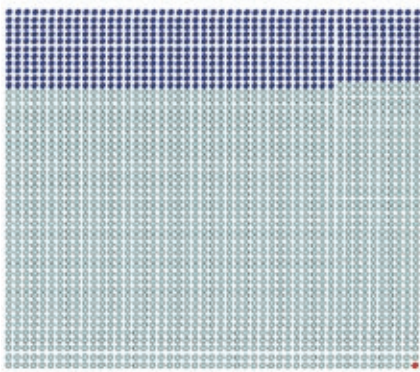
Communicating the risk of FDG PET scan. This pictorial approach may help patients understand the small risk of developing a fatal cancer as a result of this procedure. The red star indicates the risk of developing a fatal cancer (1/2500) [25]. (Used with permission of the Journal of Nuclear Medicine)
